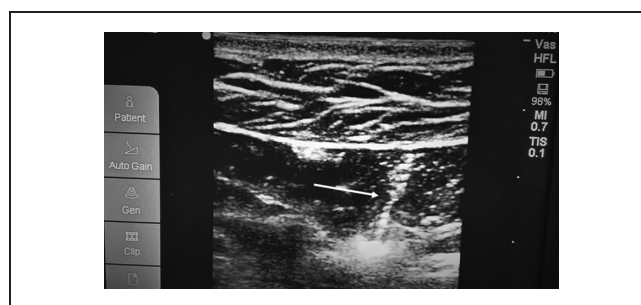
The path of the Veress needle (arrow) is visualised using real time ultrasonography
